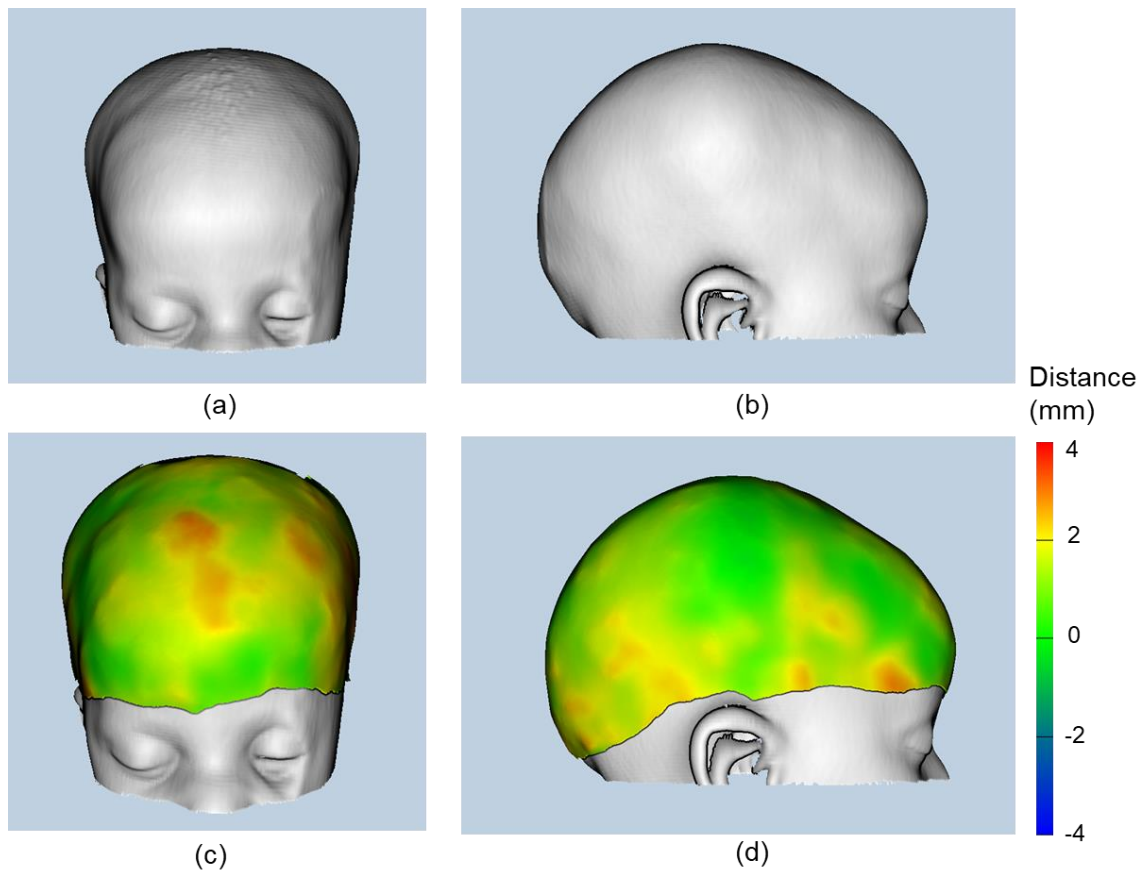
Derived models for the 3rd patient: a, b) CT; c, d) Difference distances in the 3D model between the photogrammetric solution and the registered CT.
